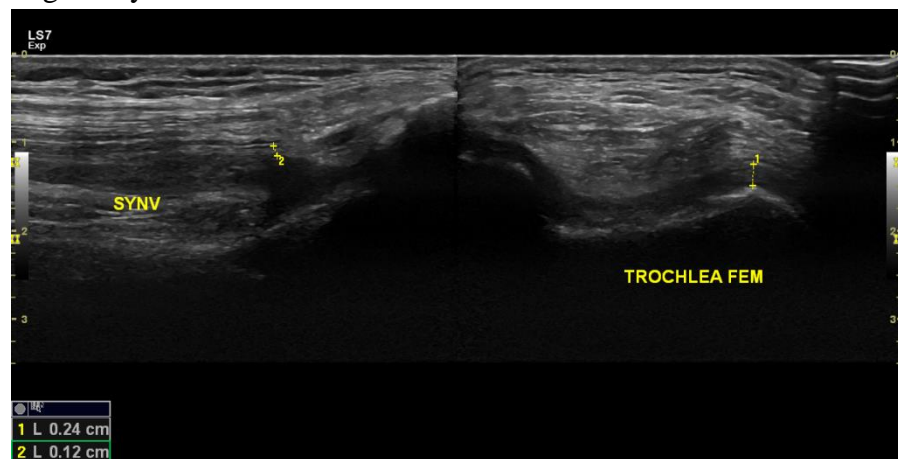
Sample image from ultrasound scanning during the study showing articular cartilage hyper echogenicity.
